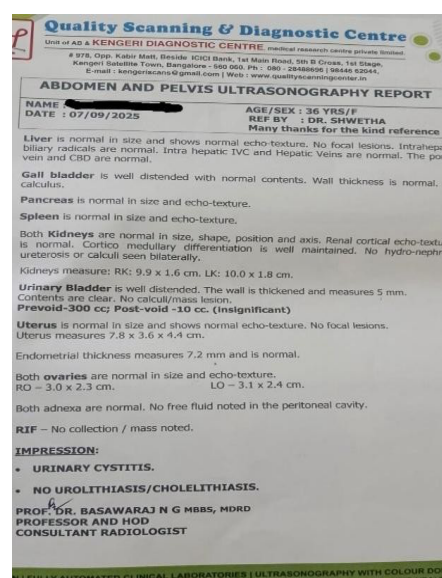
Post-treatment sonography report (07/09/2025)
